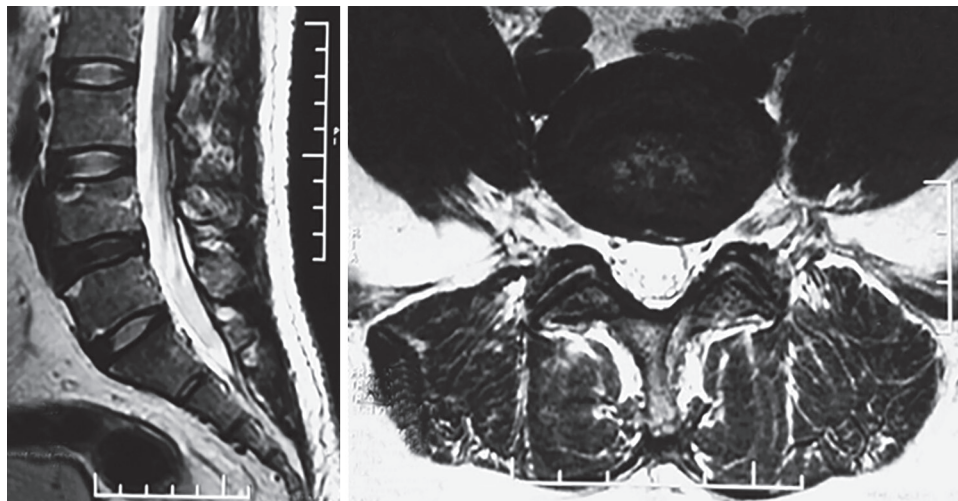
The HIZ at L4-L5 disk level on T2-weighted MRI
